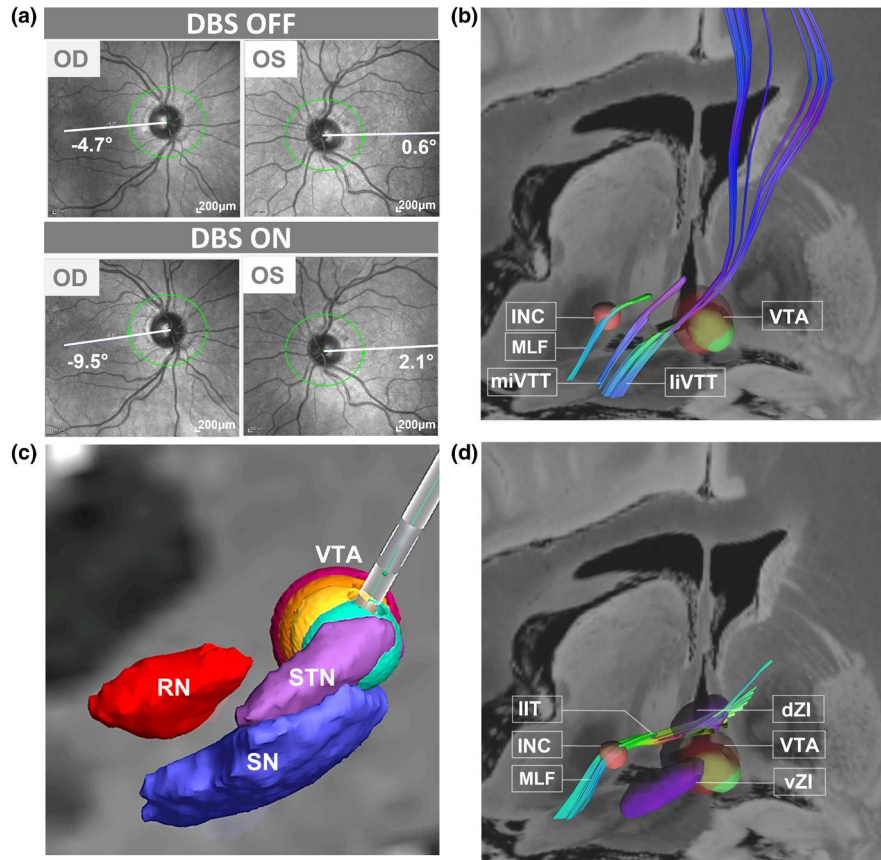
Synopsis of findings. (a) Ocular coherence tomography shows a conjugate clockwise ocular torsion in the DBS ON more than the OFF condition. (b) Electrode localization relative to neuroanatomic landmark structures SN (blue), RN (red) and STN (pink). Vestibulo-ocular motor related VTA models for amplitudes generating 5° OTR (green), 10° OTR (yellow), additional tonic upgaze (orange) and 20°–25° OTR and body retropulsion (dark red) are superimposed on an individual coronal T1w magnetic resonance image. Vestibulo-ocular motor related VTAs extend in the supero-medial direction. (c) Visualization of the VTA portions (green, minimal vestibular symptoms; red, maximal vestibular symptoms) relative to the INC, as well as the ipsilaterally ascending medial and lateral vestibular white matter tracts conveying vestibulo-perceptive signals to the cortex via the thalamic paramedian and posterolateral nuclei respectively. VTA lies remote of INC and MLF. (d) Tracing of an incerto-interstitial fibre tract connecting dorsal zona incerta and ipsilateral INC which is reached by the uppermost and medial border of symptom-associated VTA. INC, interstitial nucleus of Cajal; miVTT/liVTT, medial/lateral ipsilateral vestibulo-thalamic tract; MLF, medial longitudinal fascicle; OTR, ocular tilt reaction; RN, red nucleus; SN, substantia nigra; STN, subthalamic nucleus; VTA, volume of tissue activated; dZI/vZI, dorsal/ventral zona incerta. See Supplemental Methods for details
